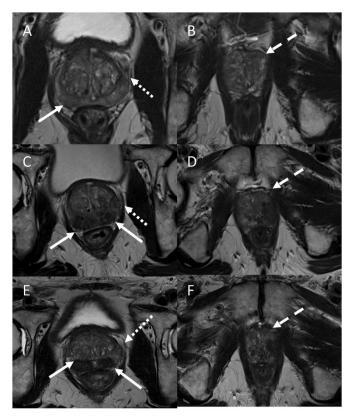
Magnetic resonance imaging (mpMRI) was performed for active surveillance, including axial T2-weighted imaging. Three T2 hypointense lesions were identified. A and B. 1.4 cm lesion in the right peripheral zone (PZ) midgland (solid arrows), a 1.2 cm left anterior transition zone (TZa) (thick dashed arrow) and 0.9 cm lesion in the left PZ midgland (small dashed arrow), corresponding to PI-RADS 4, 3, and 4 lesions, respectively. C and D. Interval increase in size of the previously noted right PZ midgland lesion, now measuring 4.2 cm and extending into the left PZ (solid arrows). This lesion did not demonstrate enhancement on DCE-MRI (not shown), with corresponding necrosis at subsequent pathology. The 1.2 cm left TZa lesion (small dashed arrow) and the 0.9 cm left PZ midgland lesion (thick dashed arrow) remained stable. E and F. Interval decrease in size of the right PZ midgland lesion, now measuring 3.4 cm with reduction of extension into the left PZ (solid arrows). The 1.2 cm left TZa lesion (small dashed arrow) and the 0.9 cm left PZ midgland lesion (thick dashed arrow) remained stable.
